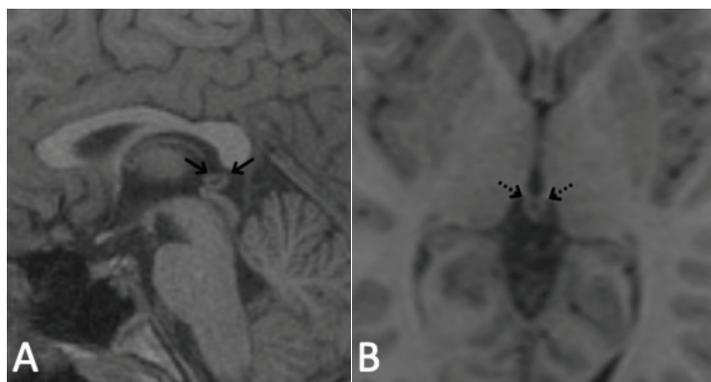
On MRI, a pineal cystic transformation consistent with true pineal cyst which appears hypointense (A) in T1-weighted sagittal sequences and (B) in T1-weighted axial sequences.
